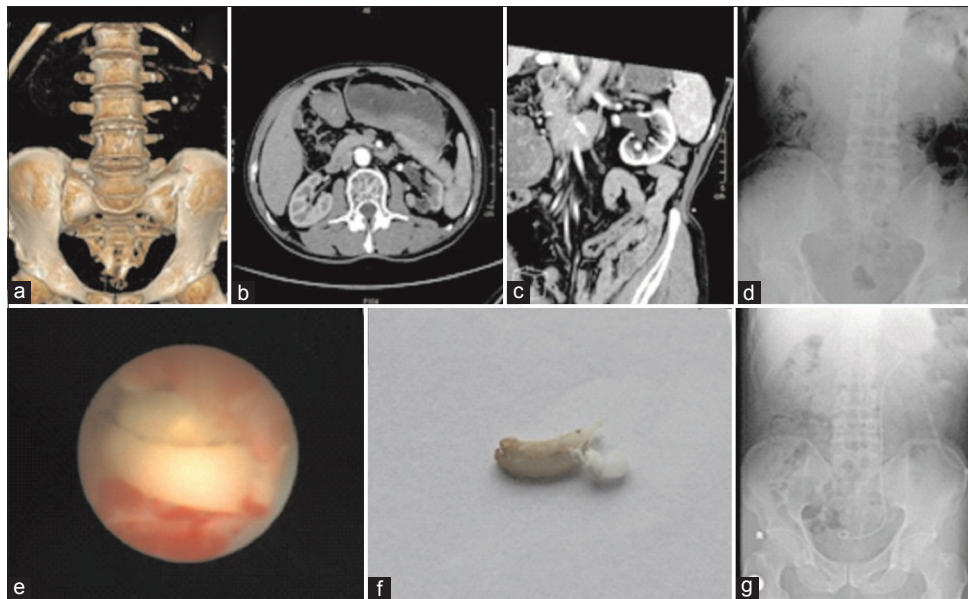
Kidney, ureter, and bladder examinations in a 71-year-old male patient. Preoperative three-dimensional reconstruction (a), cross-section (b), and coronal plane (c) computed tomography and X-ray (d) of kidney, ureter, and bladder showed multiple left renal stones with hydronephrosis. (e) Intraoperative finding of a foreign body at renal pelvis. (f) The foreign body was confirmed as Hem-o-lok clip via *in vitro* examination. (g) Postoperative X-ray of kidney, ureter, and bladder showed no significant residual stones in the left kidney.
